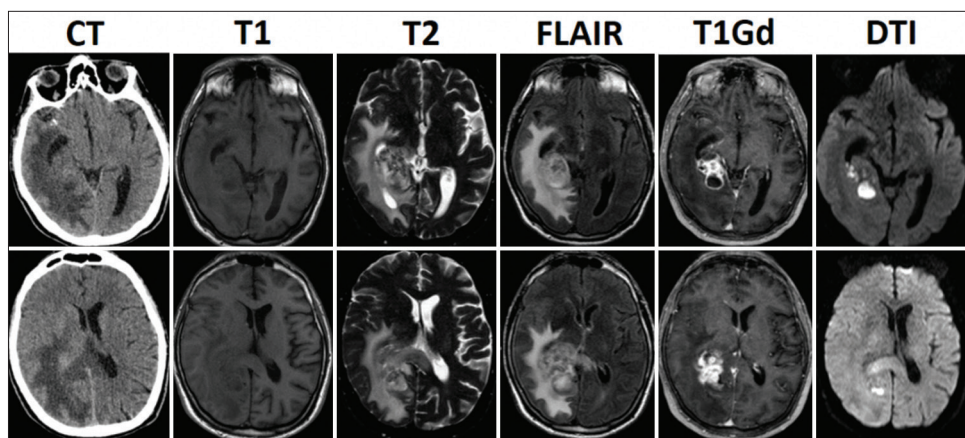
Preoperative neuroimage of patient. We present preoperative computed tomography and MR in sequences T1, T2, FLAIR, and T1 with gadolinium and diffusion. MR disclosed an expansive right temporal lesion. It was solid-cystic, hyperintense at T1, and hypointense at T2, with heterogeneous enhancement after gadolinium injection.
